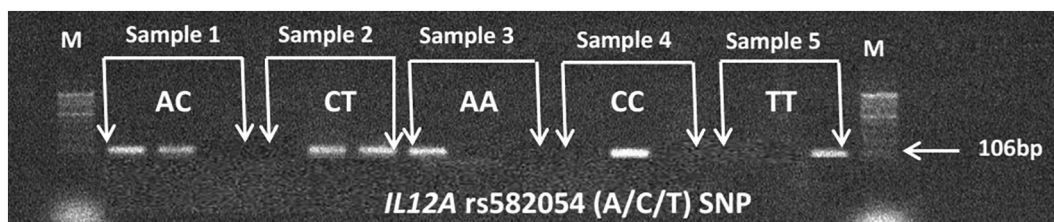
Gel electrophoresis of DNA-PCR amplified products (106 bp) for the SNP rs582054 (A/C/T) on 3% agarose (5 V/cm² for 60 min) showing genotypes for five samples. Sample 1: AC, Sample 2: CT, Sample 3: AA, Sample 4: CC, Sample 5: TT. M: DNA Ladder (100 bp).
